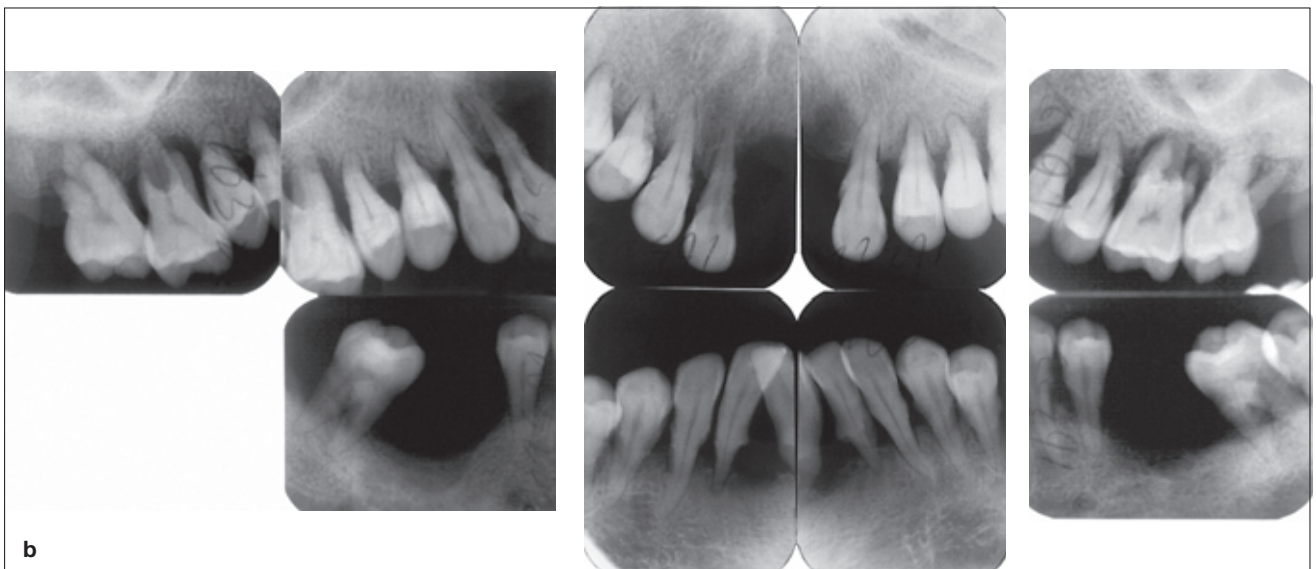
Clinical status of the patient's mother on first visit. a) Teeth 11, 21, 22, 31, 36, 41 and 46 had been lost and extensive dental calculus and gingival recession were observed. Clinical examination revealed severe attachment loss. b) Full-mouth periapical radiographs at initial examination revealed severe horizontal bone loss to the apical third of the root length. The prognosis for most of the teeth was hopeless.
